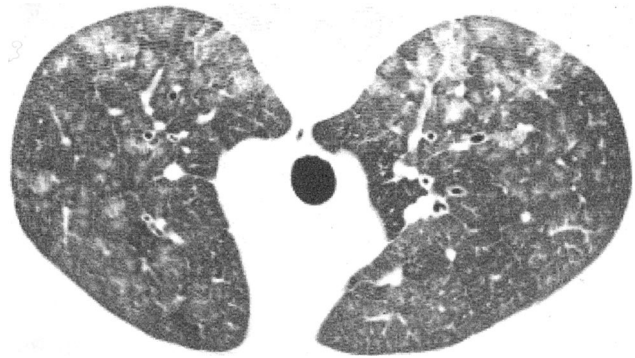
Unenhanced thin-section computed tomogram (W 1,200, L 700, 1.25 mm) shows diffuse ill-defined centrilobular nodules and prominent peribronchovascular structures. Mild air trapping was apparent on expiratory images (not shown).
